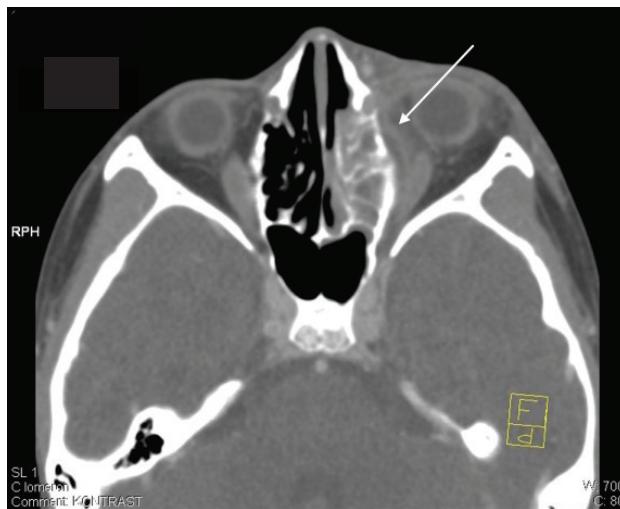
CT scan of subperiosteal abscess of the right orbit (indicated with an arrow)
